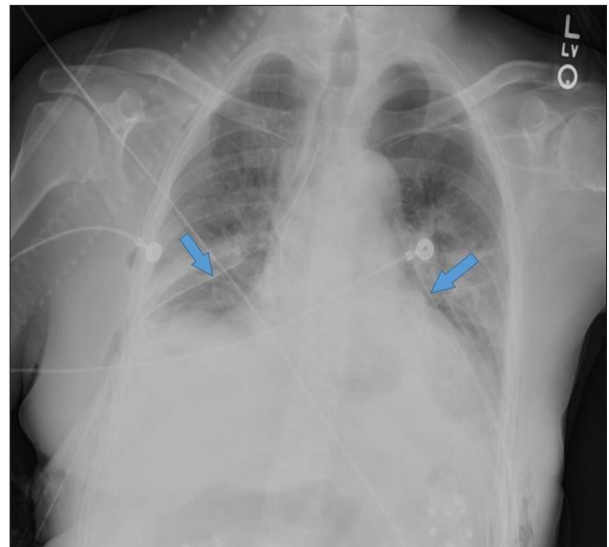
Chest x-ray revealing bilateral chest tubes (see arrows) with near resolution of bilateral pneumothorax.
